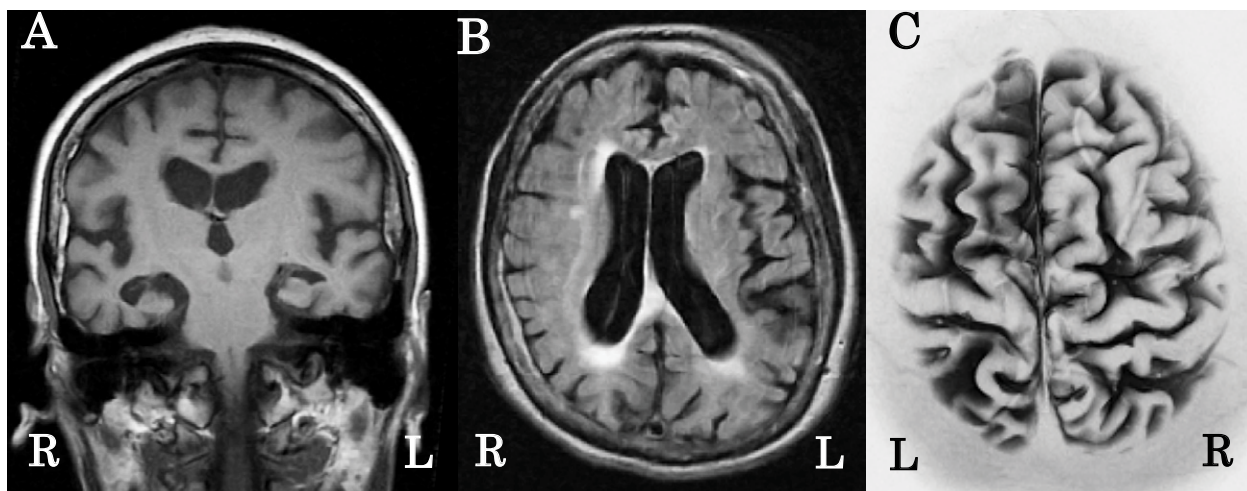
Head MRI at 57 years old revealed diffuse cortical atrophy, along with atrophy of the bilateral hippocampi and a mild degree of ventriculomegaly, more marked on the right than on the left. No findings of NPH were seen. (A) T1-weighted image, (B) fluid-attenuated inversion recovery (FLAIR) imaging and (C) surface anatomy scanning imaging
